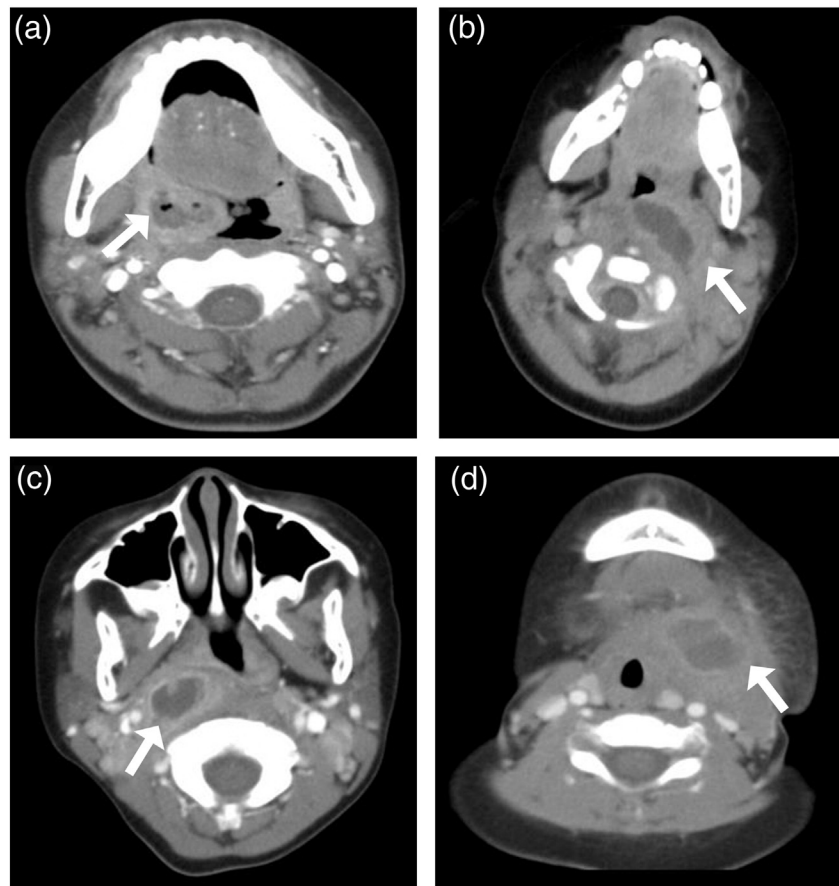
Axial computed tomography view of deep neck abscess. (a) CT scan demonstrates right peritonsillar abscess with mucosal swelling (white arrow). (b) Parapharyngeal abscess. Left peritonsillar abscess extended to parapharyngeal space (white arrow) and a mass effect on the airway. (c) Retropharyngeal abscess. Right retropharyngeal space 25×16 mm sized low attenuated lesion with peripheral wall enhancement and surrounding soft tissue swelling (white arrow). (d) Submandibular abscess. About 22×16 mm sized abscess extended to left submandibular space with myositis and cellulitis (white arrow).
